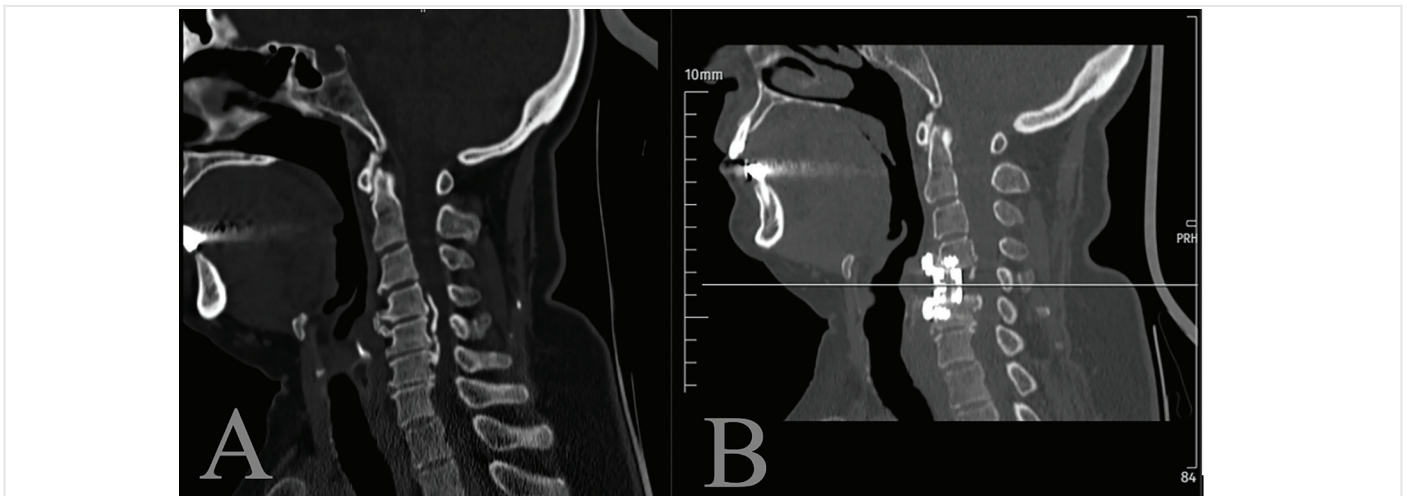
A 52-year-old male patient with C4-6 cervical spinal stenosis reconstructed with a titanium cage (preoperative mJOA score: 14). (A) Preoperative computed tomography (CT) scan showing destruction of the C4-6 posterior vertebral bodies and intervertebral discs, resulting in segmental instability. (B) Postoperative CT scan obtained 12 months after C4-6 corpectomy and titanium cage reconstruction demonstrates optimal cage positioning and satisfactory cervical stabilization (postoperative mJOA score: 17). mJOA: Modified Japanese Orthopaedic Association score
